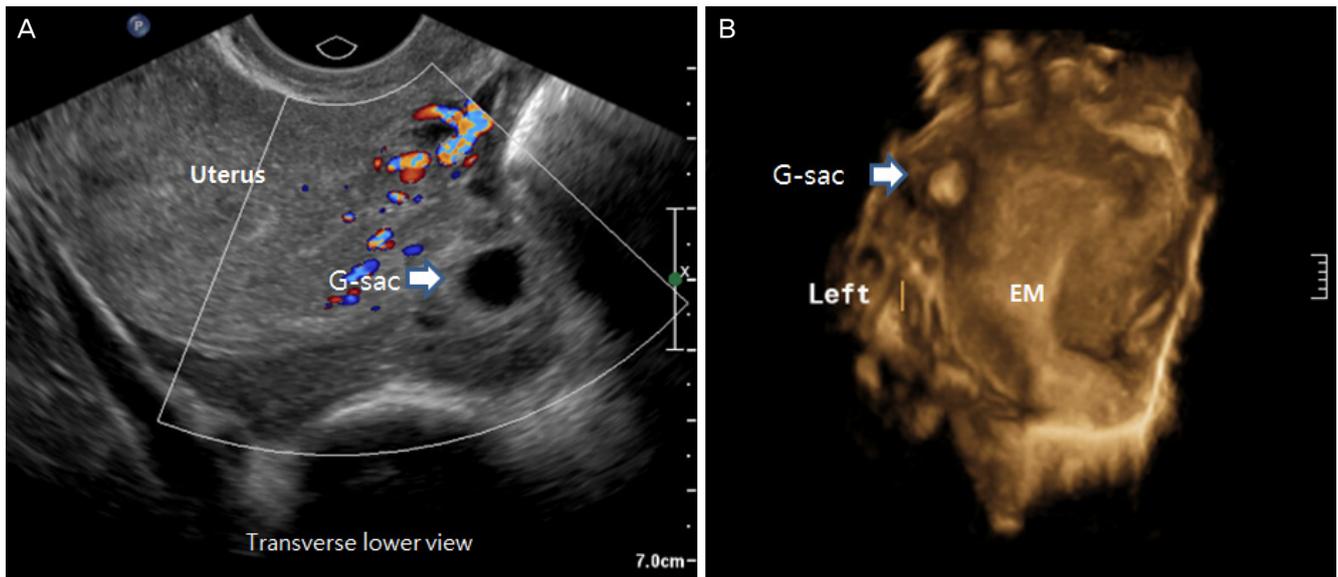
(A) Preoperative two-dimensional transvaginal sonogram revealed a gestational sac (G-sac) that was separated from the uterus, with a certain amount of hemoperitoneum, suggesting the presence of an ectopic pregnancy. (B) Three-dimensional transvaginal sonogram revealed a 1.8-cm mass located adjacent to the left cornus, clearly outside the endometrium (EM).
